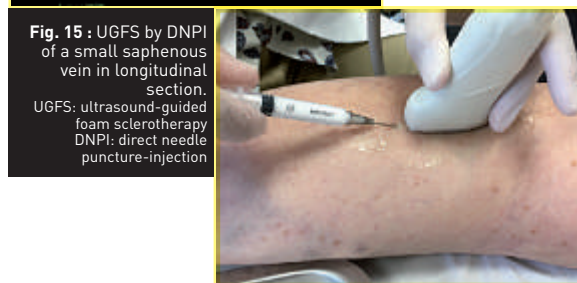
UGFS by DNPI of a small saphenous vein in longitudinal section. UGFS: ultrasound-guided foam sclerotherapy DNPI: direct needle puncture-injection
